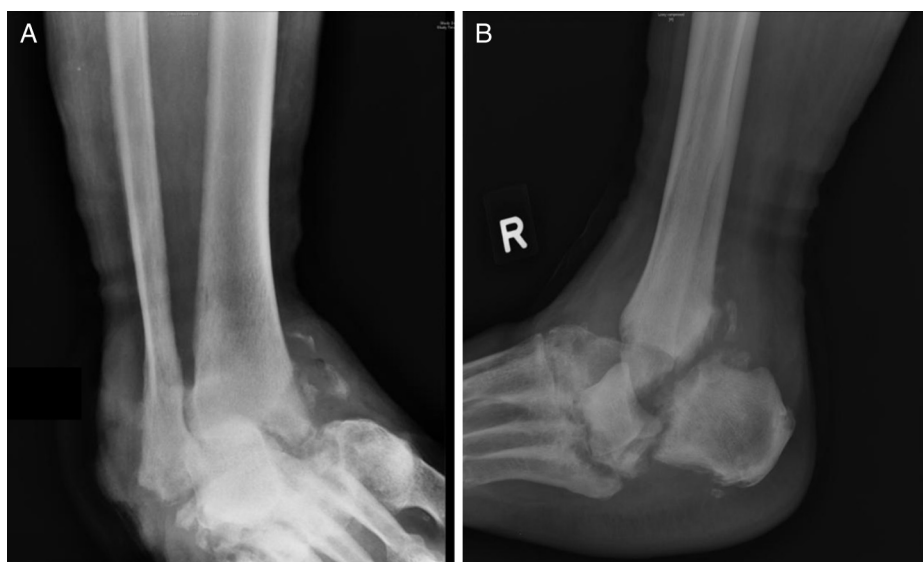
(A and B) Preoperative radiographs of the patient's right foot and ankle.
